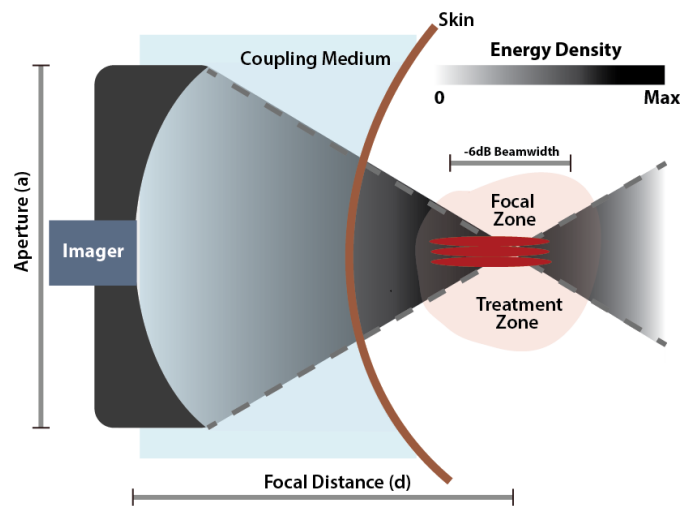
Mechanism of Focused ultrasound ablation.
